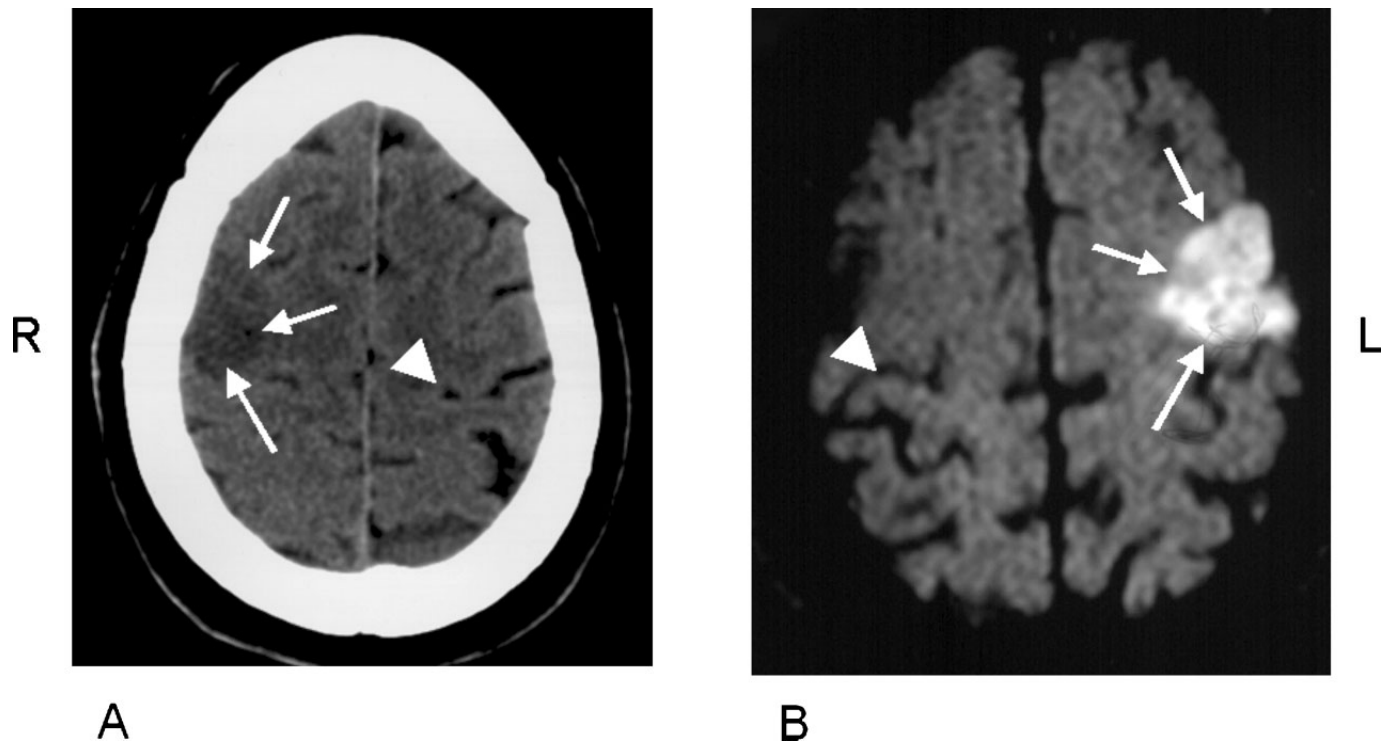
(A) A representative CT scan slice of patient 2 with the right FEF lesion, marked by three arrows. (B) Diffusion-weighted MR-imaging of patient 1 with the left FEF lesion. The anatomical localization of the FEF in humans is at the superior part of the precentral sulcus, near the caudal end of the superior frontal sulcus (Rosano *et al.*, 2003). The central sulcus is marked on the other hemisphere by a white triangle.
